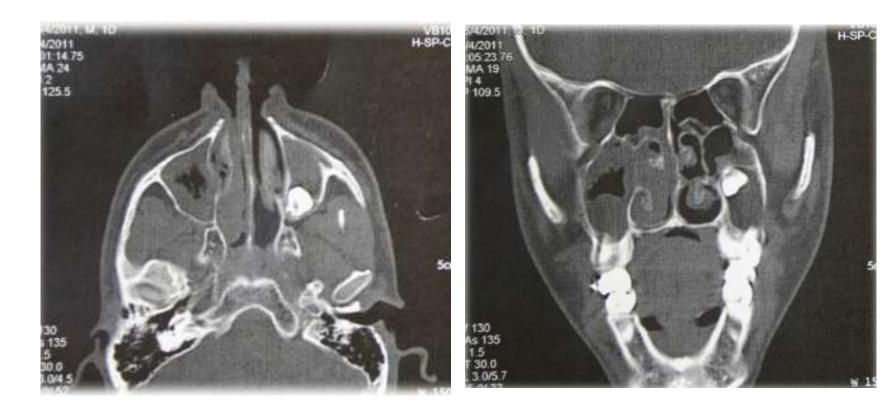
Computed tomography, the axial section
